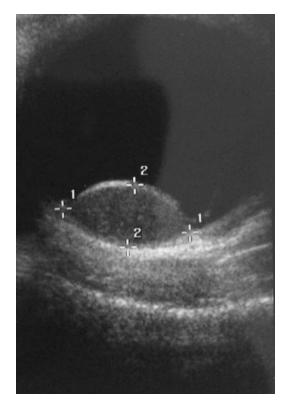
Dome-shape choroidal mass as demonstrated by B-mode ultrasonography
